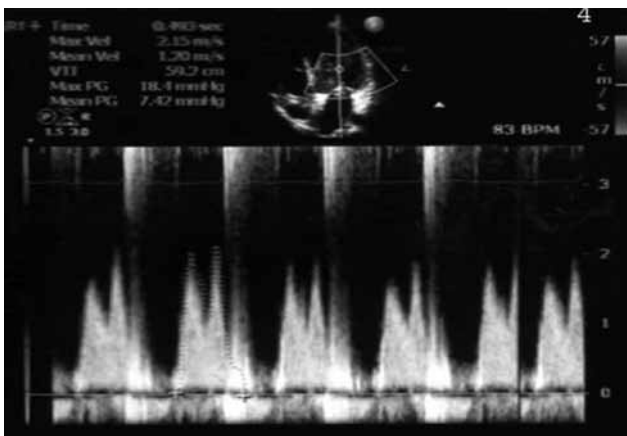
Doppler image when the peak gradient through the mitral valve increased to 18 mmHg confirming the increase in mitral insufficiency in January 2006.
